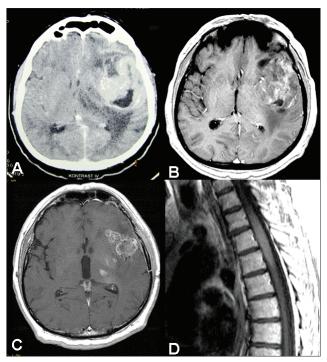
Axial CT-scan showing an heterogenous contrast enhanced fronto-insular lesion (A); axial T1-weighted images with gadolinium after neo-adjuvant chemotherapy (B), and before radiochemotherapy (C). Sagittal T1 weighted with gadolinium images showing intramedullary lesion at th5 level (D).
